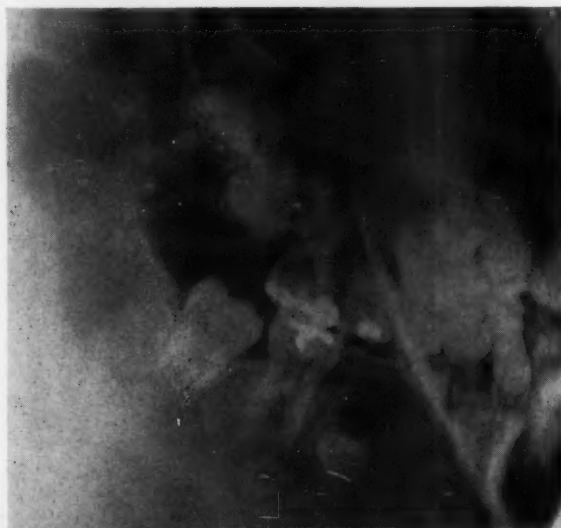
Lateral jaw roentgenogram showing overretained mandibular second deciduous molar and distal ectopic eruptive position of second premolar.
